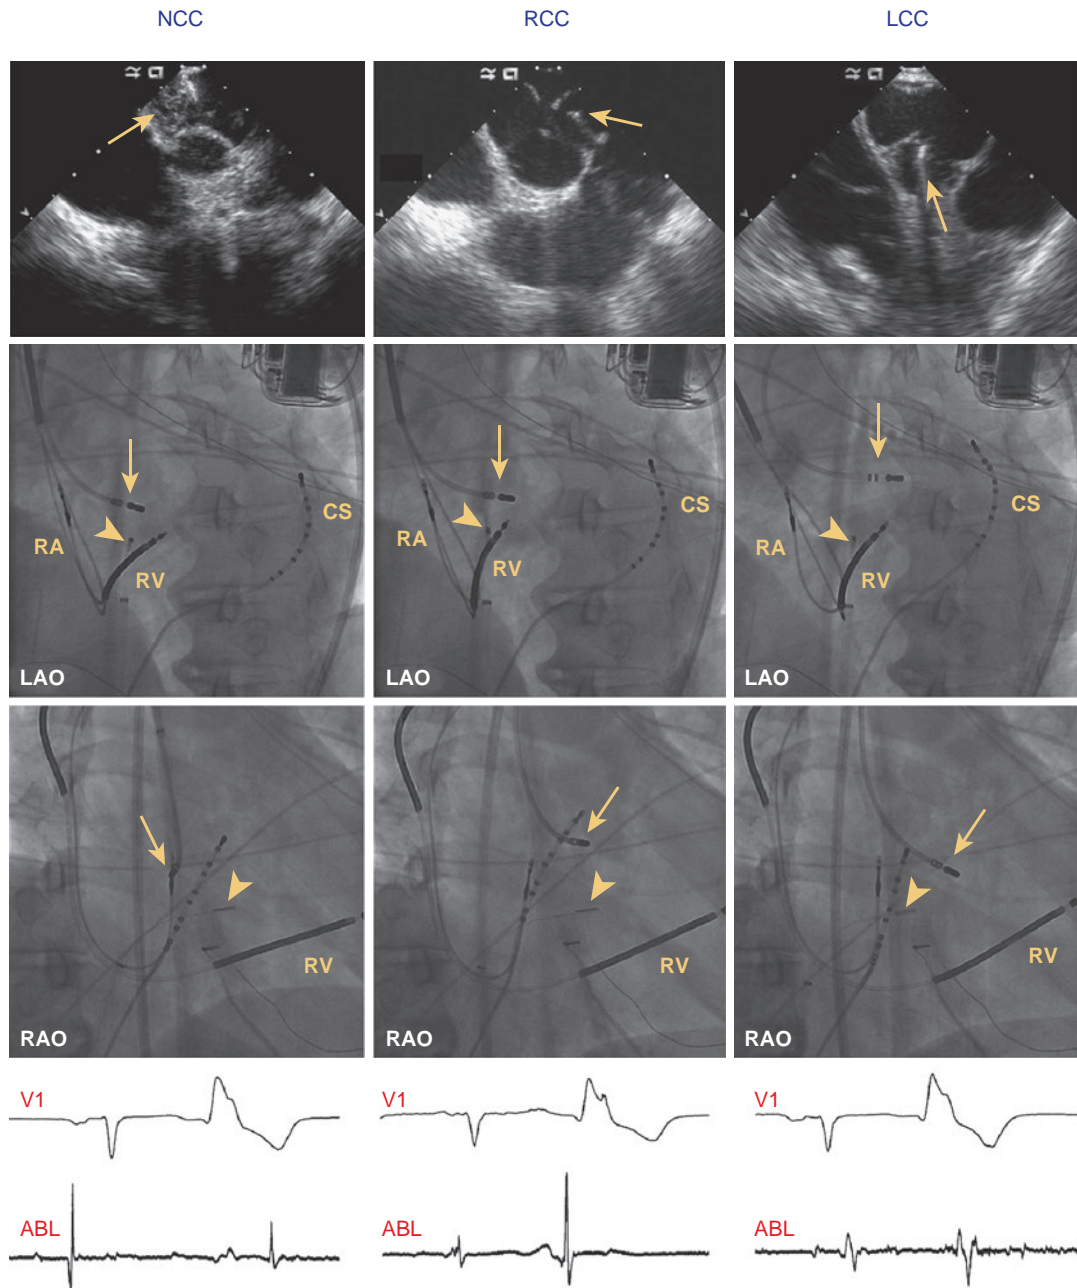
Catheter Ablation in the Aortic Root. Top, Intracardiac echocardiography (ICE) images (*top row*) and left anterior oblique (LAO) and right anterior oblique (RAO) fluoroscopic views (*middle and bottom rows*, respectively). Bottom, Intracardiac recordings. Images and recordings were obtained during mapping in the noncoronary cusp (NCC, *left panels*), right coronary cusp (RCC, *middle panels*), and left coronary cusp (LCC, *left panels*). The ablation catheter tip on ICE and fluoroscopic images is marked by yellow arrows. Cross-sectional ICE images of the aortic valve were obtained with the ICE catheter (*arrowheads*) positioned at the His bundle region of the right ventricular (RV) septum. Right atrial (RA) and RV leads of an implantable cardioverter-defibrillator and a decapolar catheter positioned in the coronary sinus (CS) are marked. In the NCC, large near-field atrial and small far-field ventricular electrograms are recorded by the ablation (ABL) catheter tip. The recorded electrograms from the RCC show a large ventricular electrogram and far-field atrial electrogram. In the LCC, large ventricular and small, far-field atrial electrograms are recorded.
